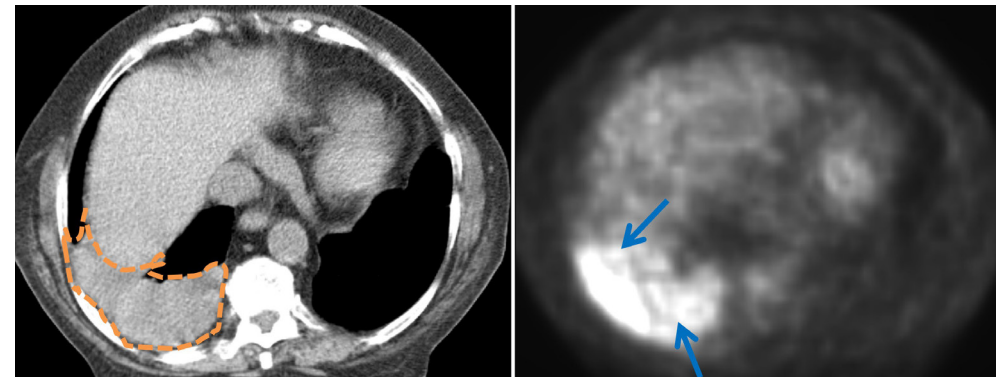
Left image: transversal slice of a CT scan of a lung cancer patient showing in the right lung collapsed lung tissue (orange dashed contour), called atelectasis, hampering identification of tumor boundaries. Right image: transversal slice of the corresponding PET scan showing high FDG uptake in a primary tumor in the right lower lobe; GTV delineation is hampered by the presence of inflammation within atelectasis (blue arrows) and tumor boundaries remain unclear.
